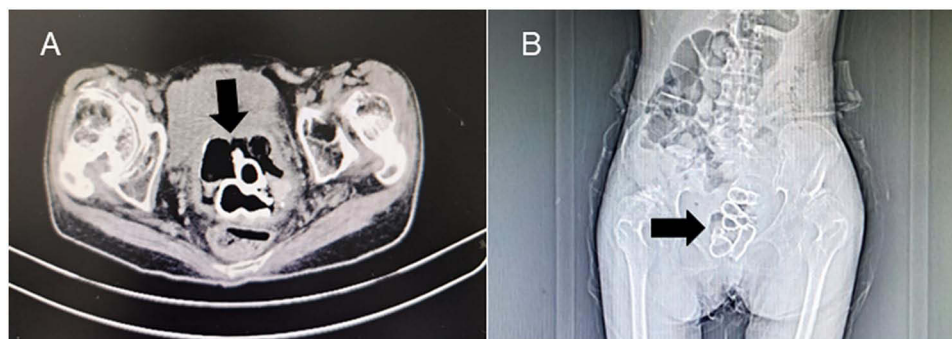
Preoperative abdominopelvic CT scan. (A and B) Irregular hyperdense lesion (arrows) within the pelvic cavity, suspicious for a foreign body.
